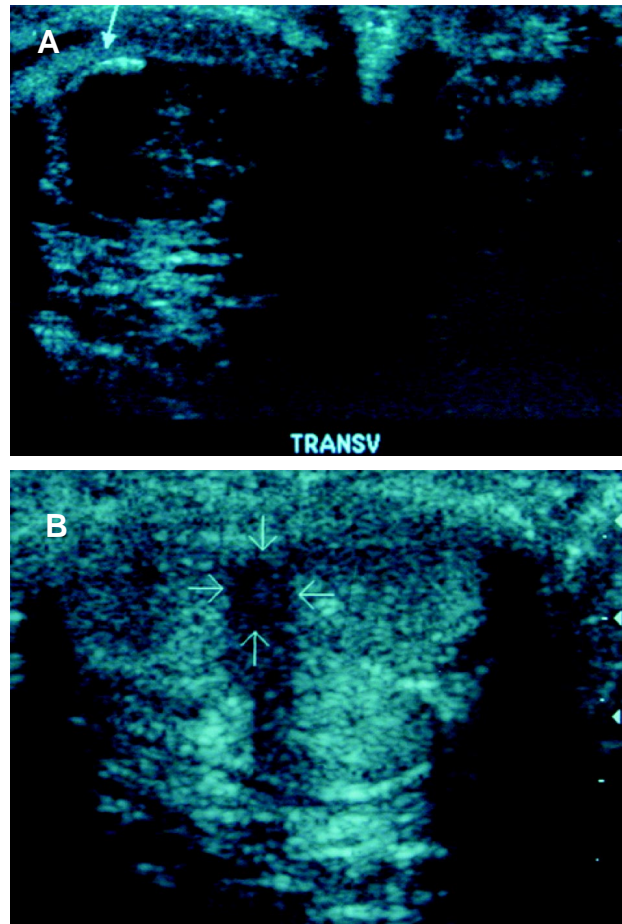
A) Ultrasound showing Peyronie's plaque. Before extracorporeal shockwave therapy. B) Ultrasound after 3 extracorporeal shockwave therapy sessions.
